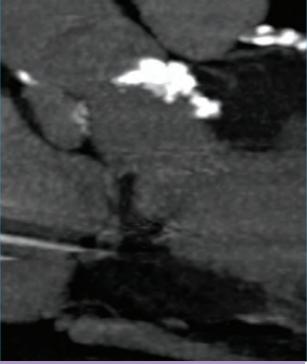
Pre-procedural CT scan.
